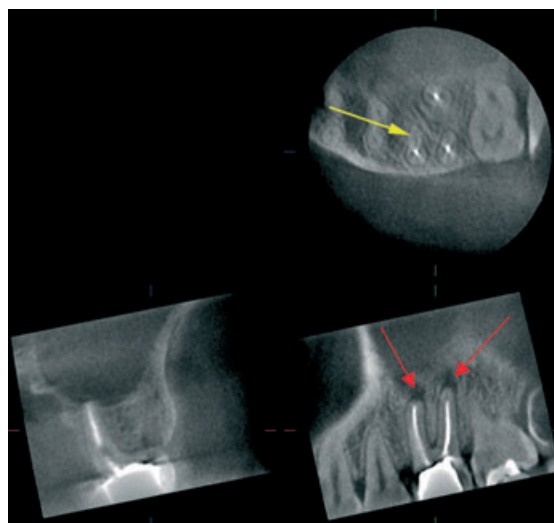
A limited volume CBCT scan using the 3D Accuitomo scanner has been taken of the maxillary left quadrant to manage tooth 26. The axial scan clearly shows an untreated second mesiobuccal canal (yellow arrow), the sagittal scan reveals periapical radiolucencies (red arrows) associated with the mesiobuccal and distobuccal roots. The coronal slice reveals that the apex of the palatal root appears to be healthy. Courtesy of J. Morita GmbH, Dietzenbach, Germany.
